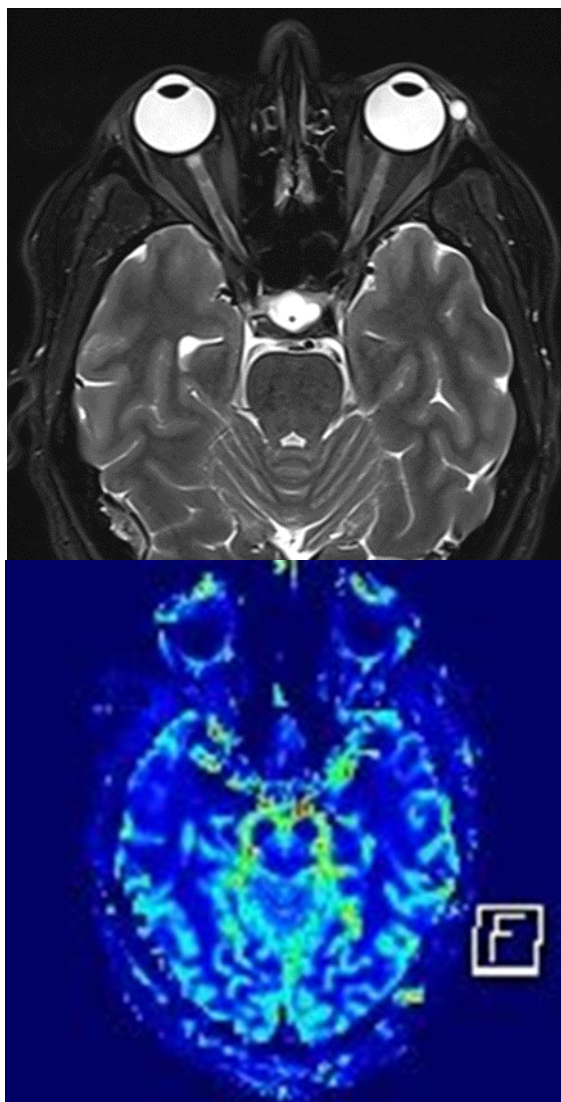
Left lacrimal gland cyst on MRI tomogram
